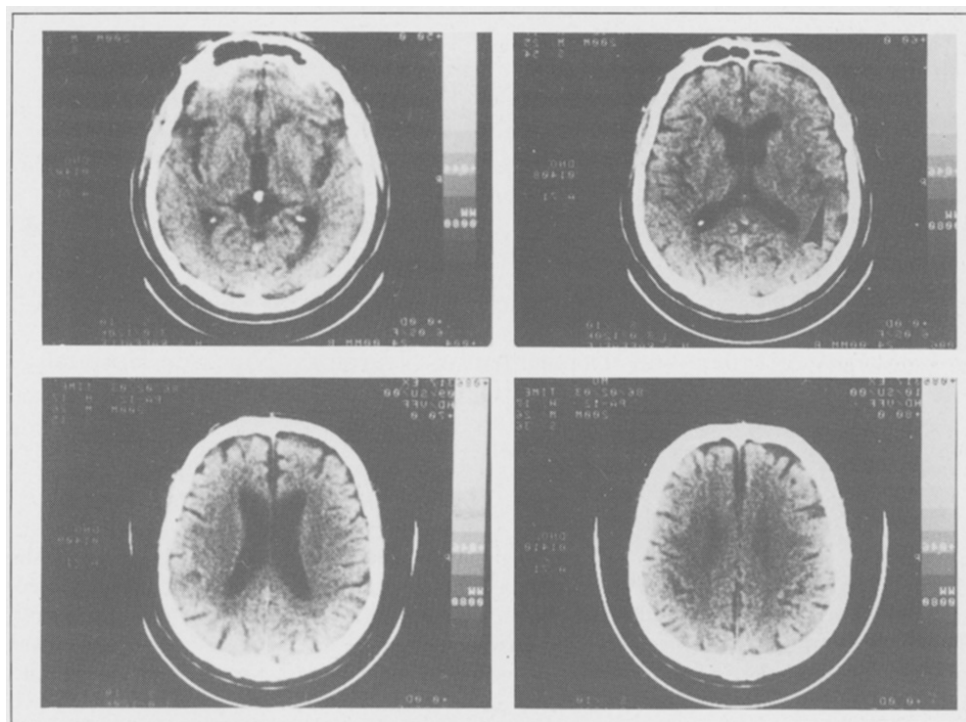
(a) — Case 1, CT scan: small hypodense lesion in the right insula (arrow).
